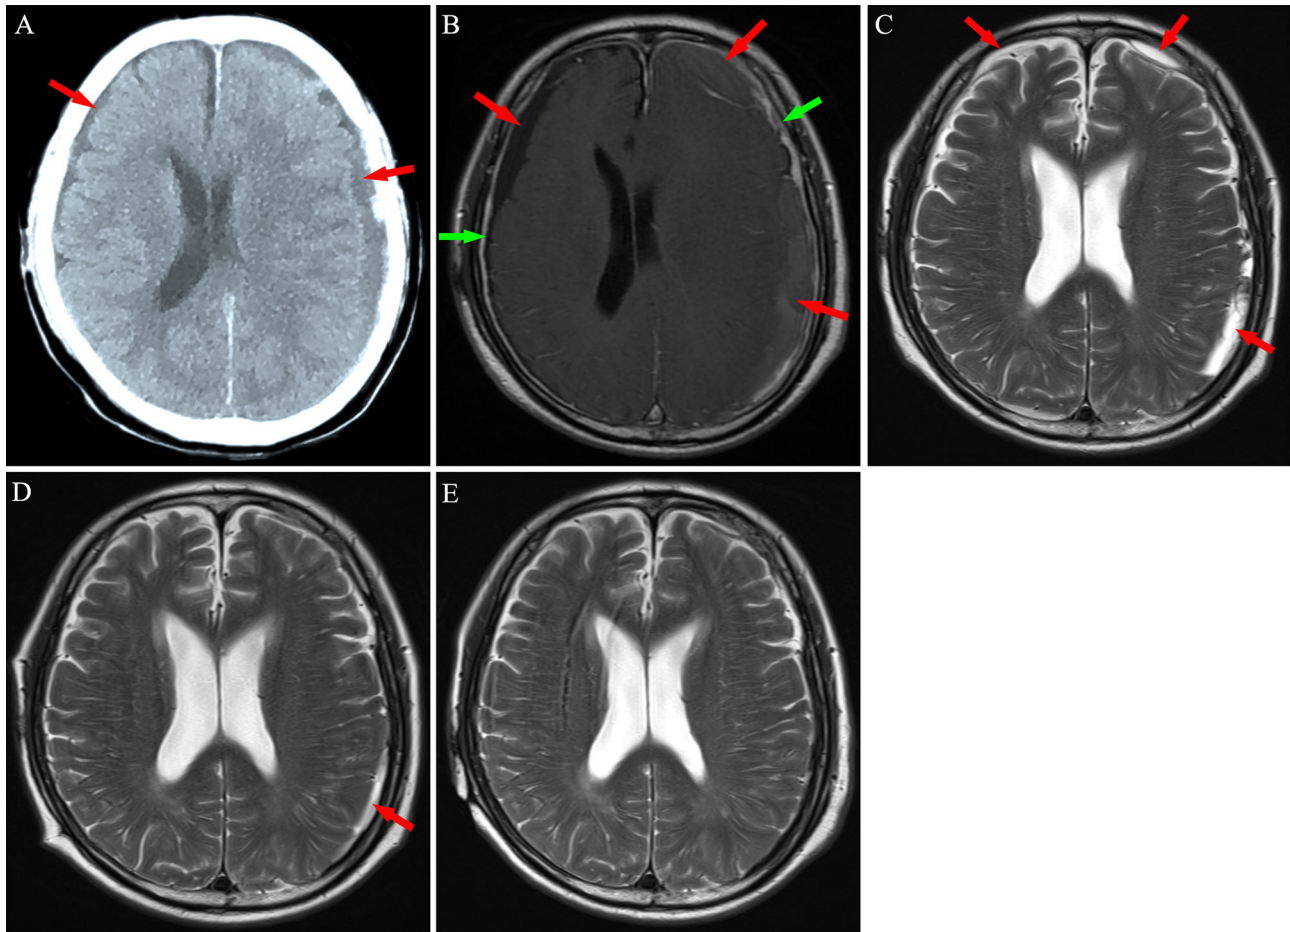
Neuroimaging findings for Patient 3. (A) Computed tomography revealed bilateral chronic subdural hematoma (red arrows). (B) After 2 weeks of atorvastatin treatment plus low-dose dexamethasone, magnetic resonance imaging revealed an increase in the hematoma, with significant enhancement of the dura mater (green arrows) post-injection of contrast agent. (C, D) After chemotherapy, subdural mass was significantly absorbed in 8–14 weeks. (E) A 5 months follow-up MRI exhibited no hematoma in the subdural space.
